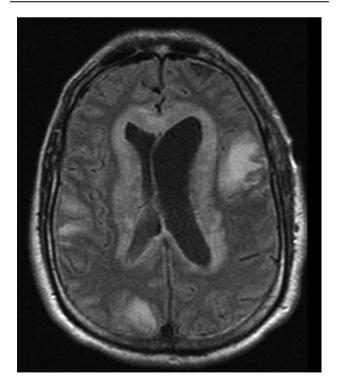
Magnetic resonance imaging 2 weeks later. Axial T2 FLAIR shows a thick rind of periventricular hyperintensity as well as focal right parietal and bilateral frontal lobe lesions.
